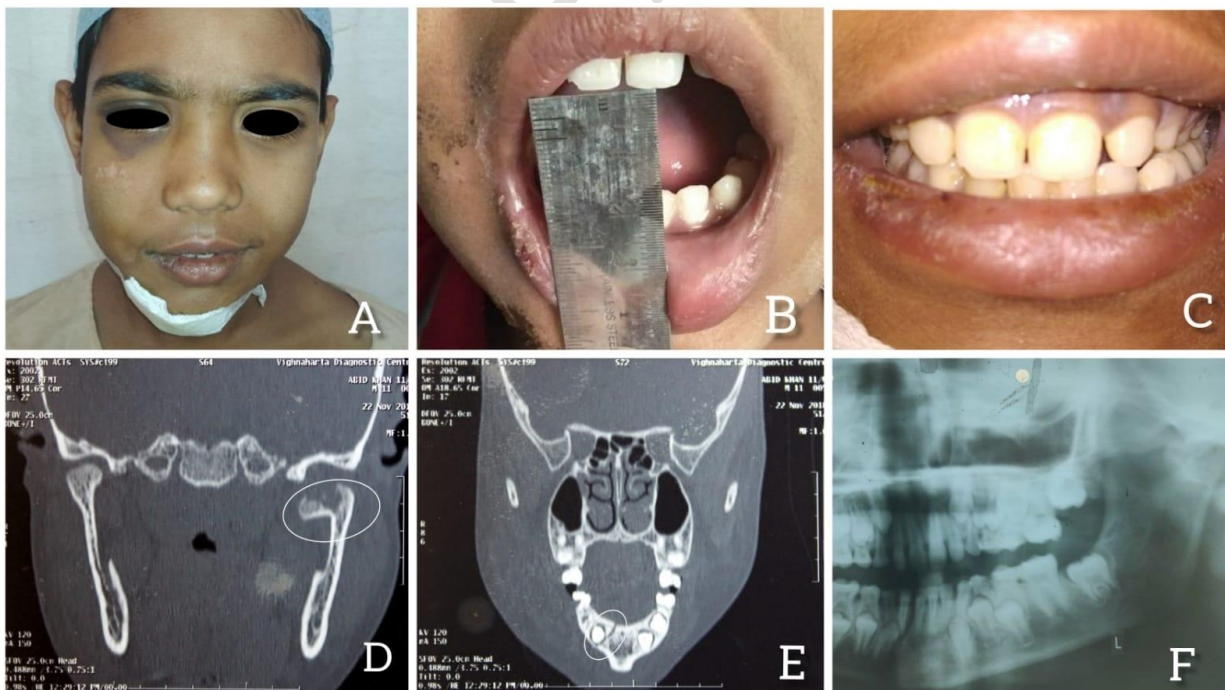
Case-Report 1, A, B, C - Pre-operative Clinical Photographs; D, E, F - Pre-Operative Radiographs.
